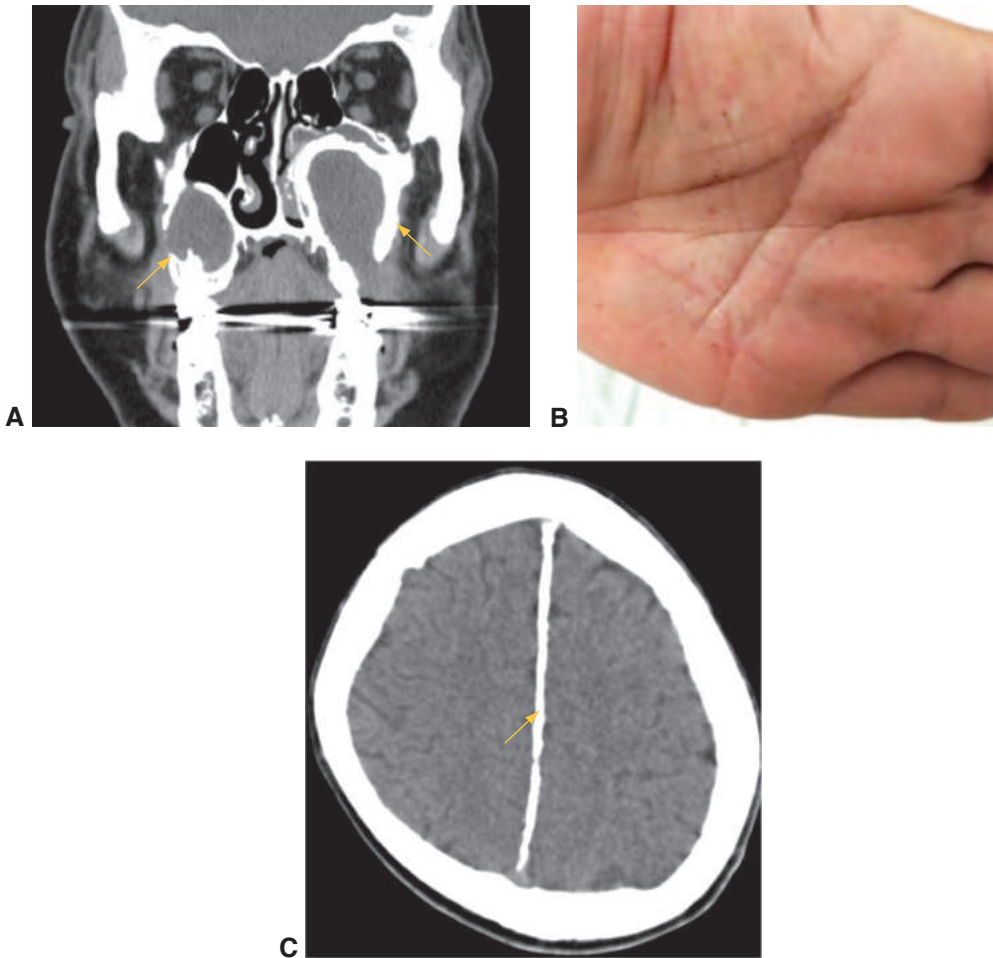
Basal cell nevus syndrome. A, Odontogenic cysts of the maxilla. B, Palmar pits appear as punctate, reddish depressions on the palms. C, Calcified falx cerebri seen on CT imaging. (Parts A and B courtesy of Pete Setabutr, MD.; part C courtesy of Steven M. Couch, MD.)
